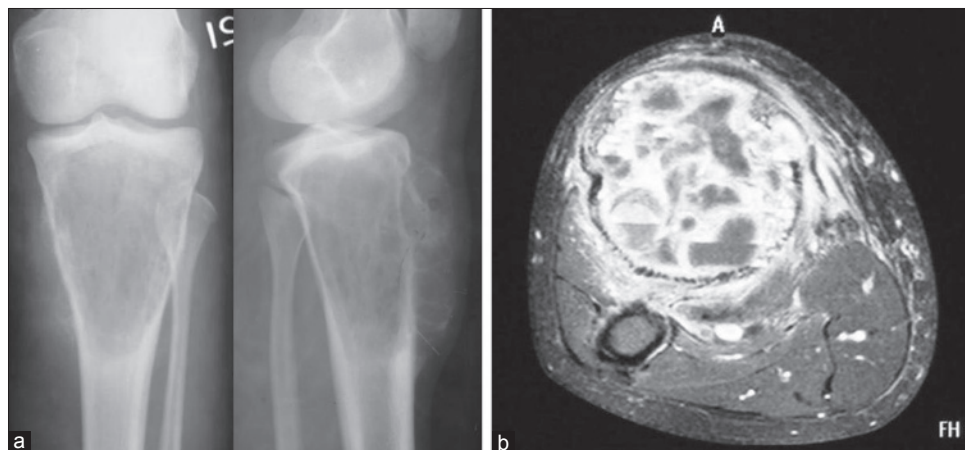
Telangiectatic type of osteosarcoma of the proximal tibia: (a) X-ray anteroposterior and lateral views showing lysis and expansion (b) MRI showing fluid levels
